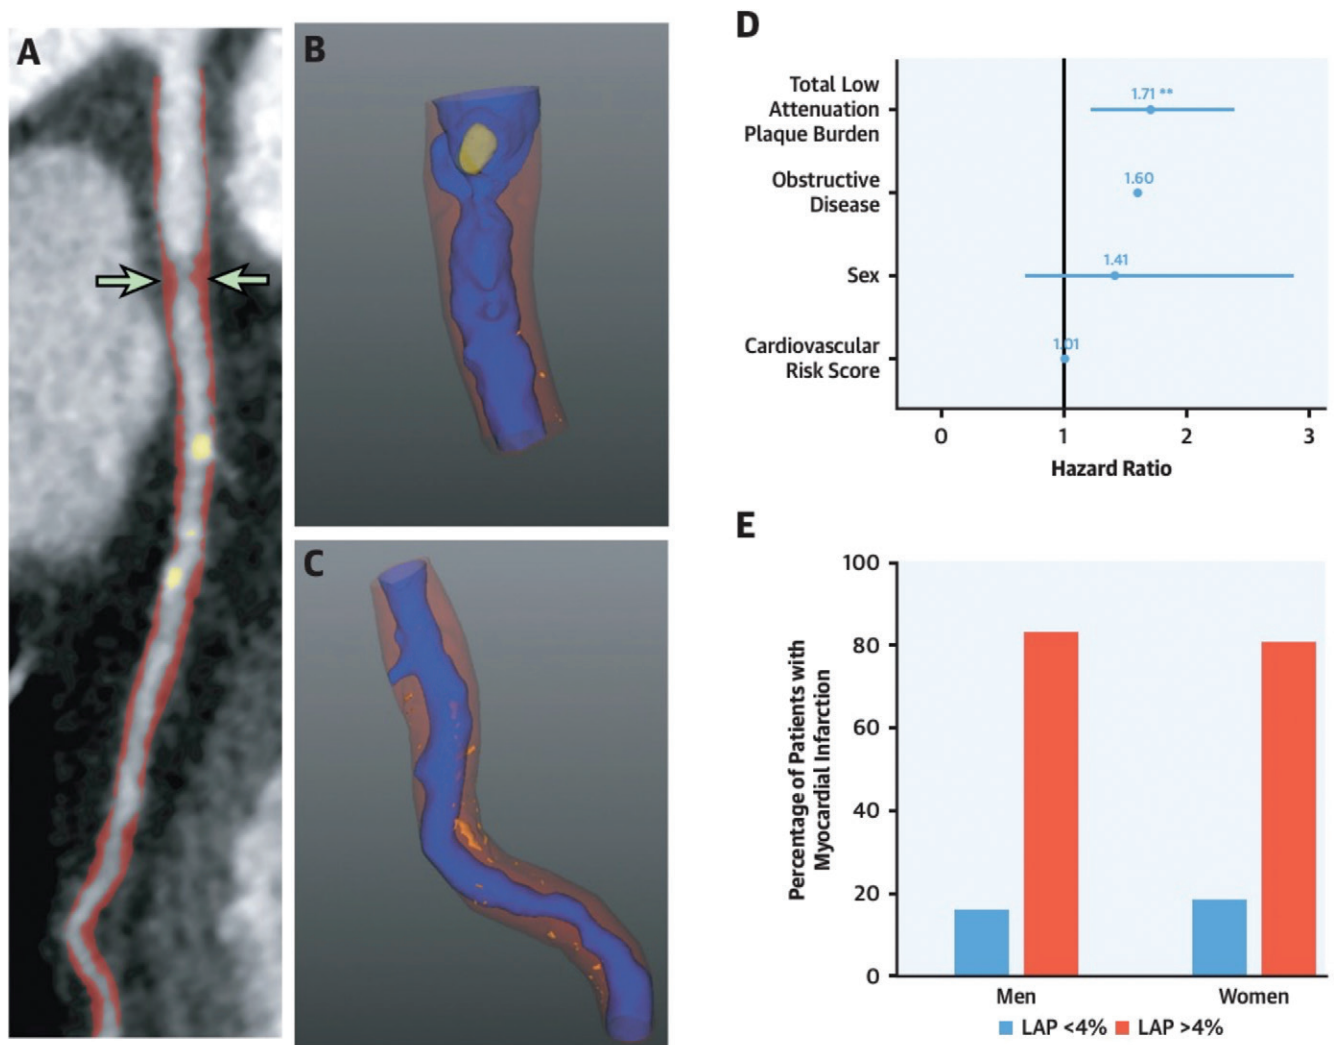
In the SCOT-HEART (Scottish CT of the Heart) trial including 1769 patients (57% were men), coronary stenosis severity, adverse plaque features, and quantitative plaque measurements were assessed for sex differences. Coronary artery disease (CAD) and atherosclerotic plaque of all subtypes were more prevalent in men than in women. The incidence of myocardial infarction (MI) over a median follow-up duration of 4.7 years was 1.4% for women and 3% for men. The latter had a higher calcific burden but similar total, noncalcified, and low-attenuation plaque burdens compared with women. In a multivariate analysis adjusted for sex, cardiovascular risk score, coronary calcium score, and obstructive CAD, low attenuation plaque was independently associated with MI. (A) Curved planar reformatted image from coronary CT angiography in a 58-year-old-woman shows obstructive disease in the left anterior descending artery (arrows) with diffuse noncalcified plaque (red) and calcified plaque (yellow). (B, C) Three-dimensional reformatted images of the proximal (B) and mid-distal (C) left anterior descending artery show noncalcified (red), low-attenuation (orange), and calcified (yellow) plaque and coronary lumen (blue). (D, E) Results calculated from a multivariate analysis (*) show low-attenuation plaque (LAP) burden as a predictor of subsequent MI (D) and the percentage of women or men with MI who had low-attenuation plaque above or below 4% (E). (Adapted, under a CC BY license, from reference 6.)
